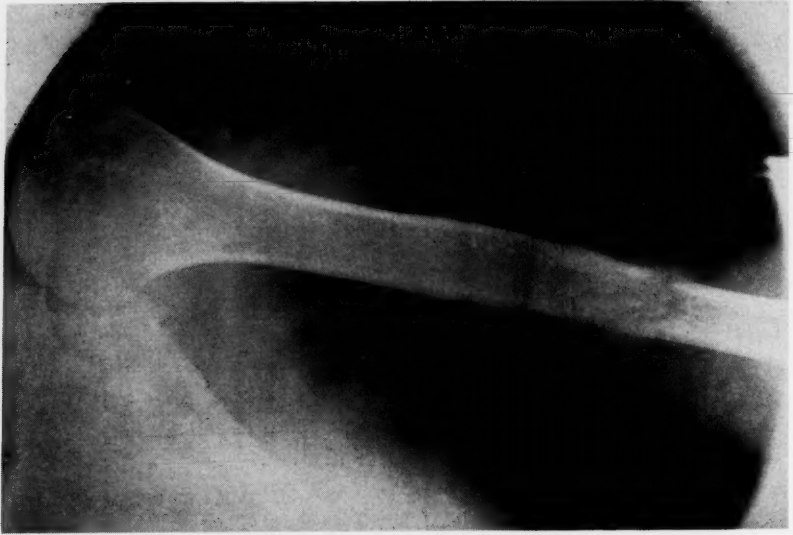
Roentgenogram of the same patient as shown in Figure 6, six weeks after the application of the hanging case.
